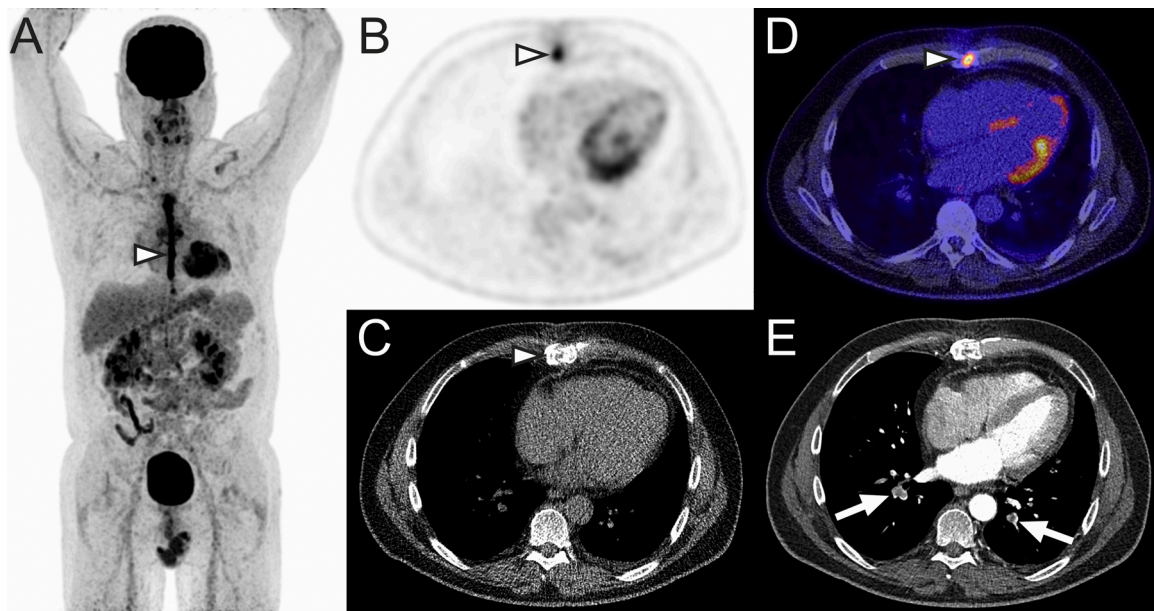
A 55-year-old man with a history of coronary artery bypass surgery and recent endoscopic mucosal resection of an esophageal cancer. Low-dose FDG-PET/CT and concomitant full-dose contrast-enhanced CT were performed for staging purposes. Coronal maximum intensity projection FDG-PET (A), axial FDG-PET (B), axial low-dose CT (C), axial fused FDG-PET/CT (D), and axial full-dose contrast-enhanced CT (E) are demonstrated. Low-dose PET/CT showed physiologically increased FDG uptake at the sternotomy site (A-D, arrowheads), but otherwise no signs of metastatic disease. Contrast-enhanced CT showed emboli in both lower lobes (E, arrows), which were not visible on low-dose FDG-PET/CT. These pulmonary emboli were not described in the original report. This perceptual error was corrected with an addendum five days after authorization of the original report.
